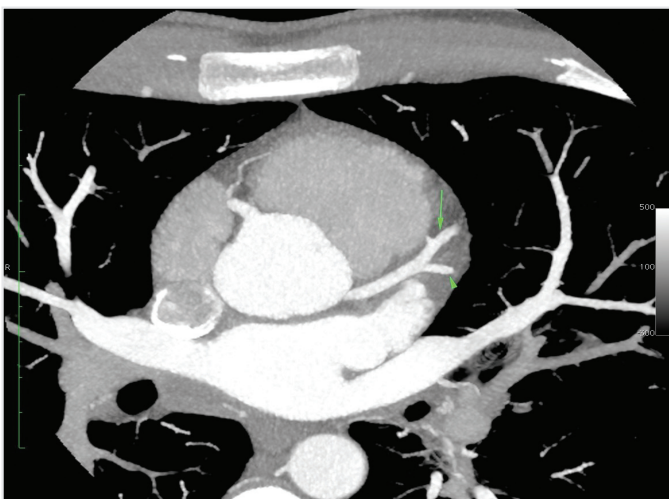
Coronary computed tomography angiography shows a long left main coronary artery, normal left anterior descending (arrow), first diagonal artery (arrowhead), and absence of left circumflex artery with superdominant right coronary artery
